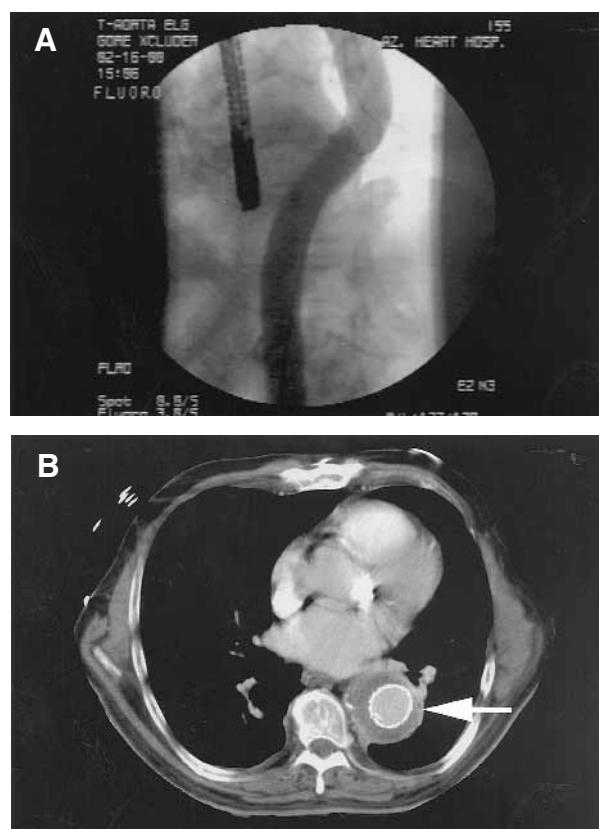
A, Angiogram shows adequate endoluminal stent graft placement. B, CT scan of thoracic stent graft after procedure.
